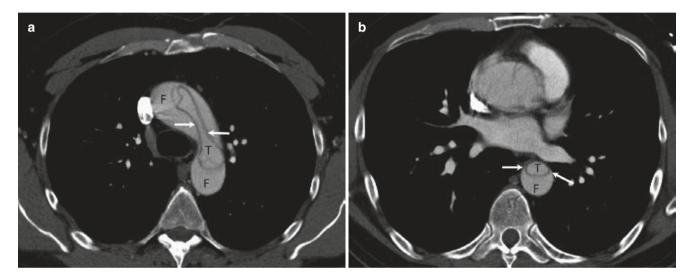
Circumferential dissection and "beak" sign. (a) Axial CT aortogram image shows circumferential dissection flap (arrows). (b) CT image from midthorax shows a "beak" sign (arrows) in false lumen. T true lumen, F false lumen
